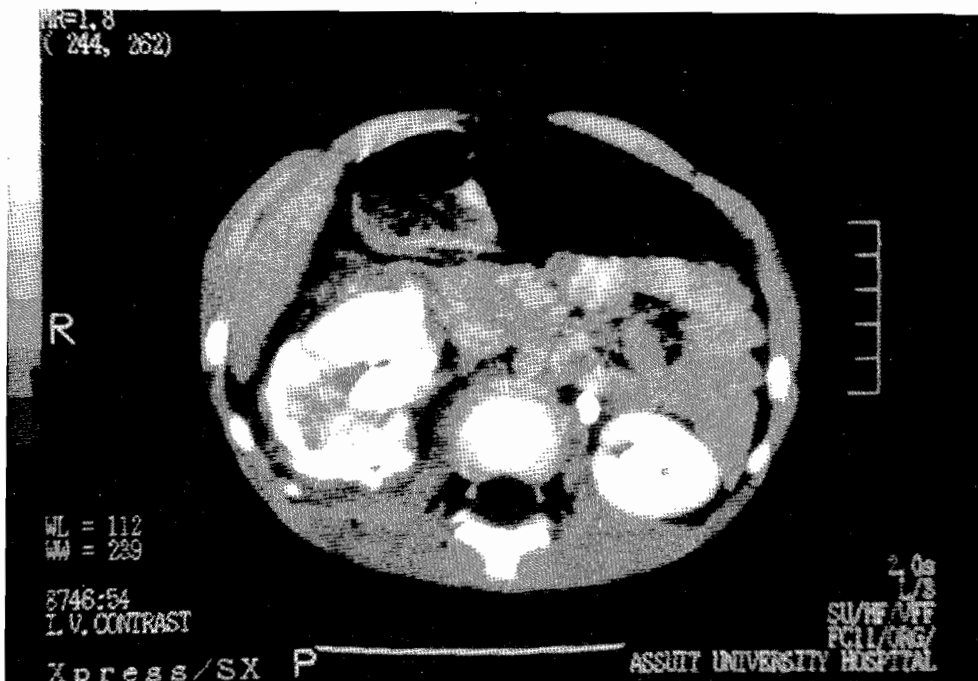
CT scan of an 8-year-old patient done immediately after blunt trauma. It shows dye extravasation and a deep laceration of the right kidney.
